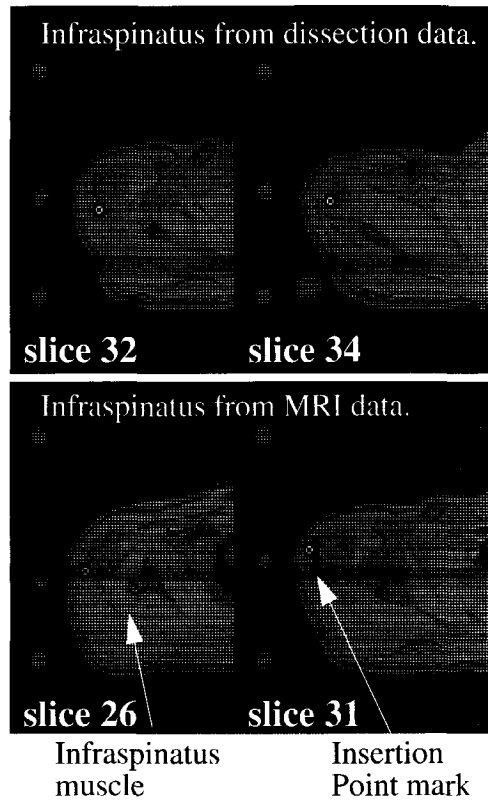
MRI images of Infraspinatus muscle. The slice thickness of this scan is 5 mm.
